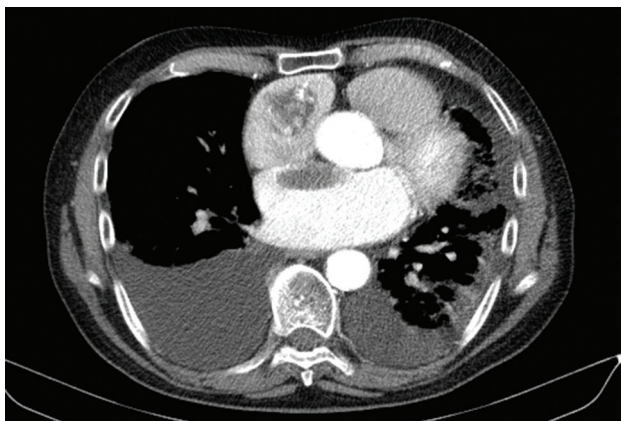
Computed tomography image showing hypodense avascular left atrial masses suspected of thrombi and hyperdense possible vascular right atrial mass.
